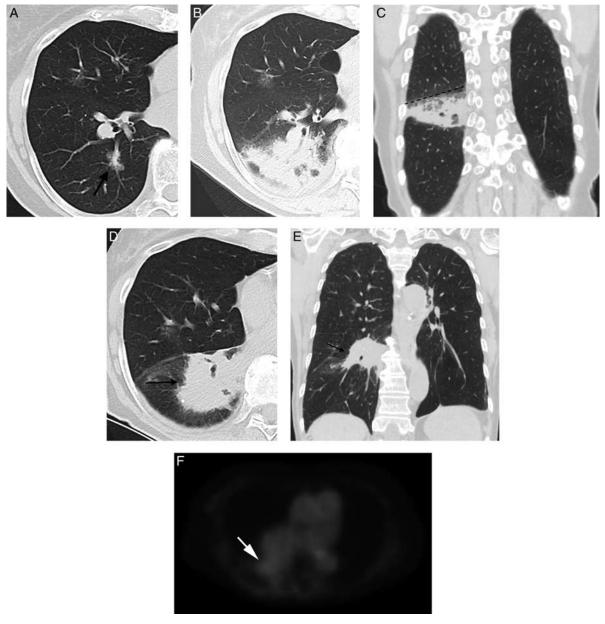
Post-SBRT CT changes. A, Baseline contrast-enhanced axial CT image shows left lower lobe part-solid lung neoplasm (arrow), before treatment with SBRT. B, Contrast-enhanced axial CT image, 3 months post-SBRT, shows diffuse consolidation pattern of acute post-SBRT change. C, Corresponding contrast-enhanced coronal CT image shows linear border (dashed line) of consolidation relating to radiation field. D, Contrast-enhanced axial CT image 2 years post-SBRT demonstrating late mass-like SBRT change with loss of linear border (arrow). E, Corresponding coronal CT image of late mass-like SBRT change (arrow). F, Axial PET image 2 years post-SBRT demonstrates uptake in the right lung opacity similar to mediastinal blood pool, a finding consistent with mass-like fibrosis (arrow).
